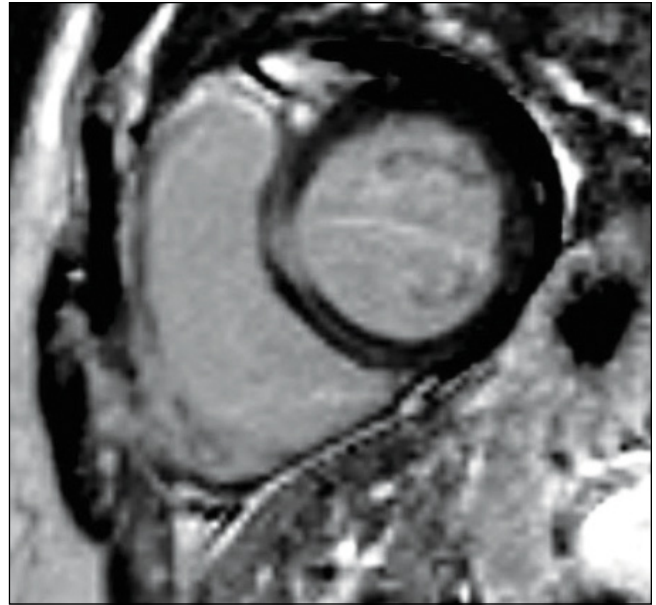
Cardiac MRI showing delayed enhancement with a mid-myocardial stripe in the basal septum.
